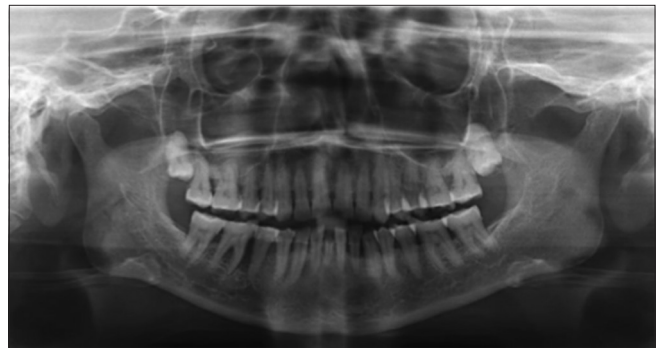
Orthopantomogram showing generalised horizontal loss of bone in 45 46 regions
